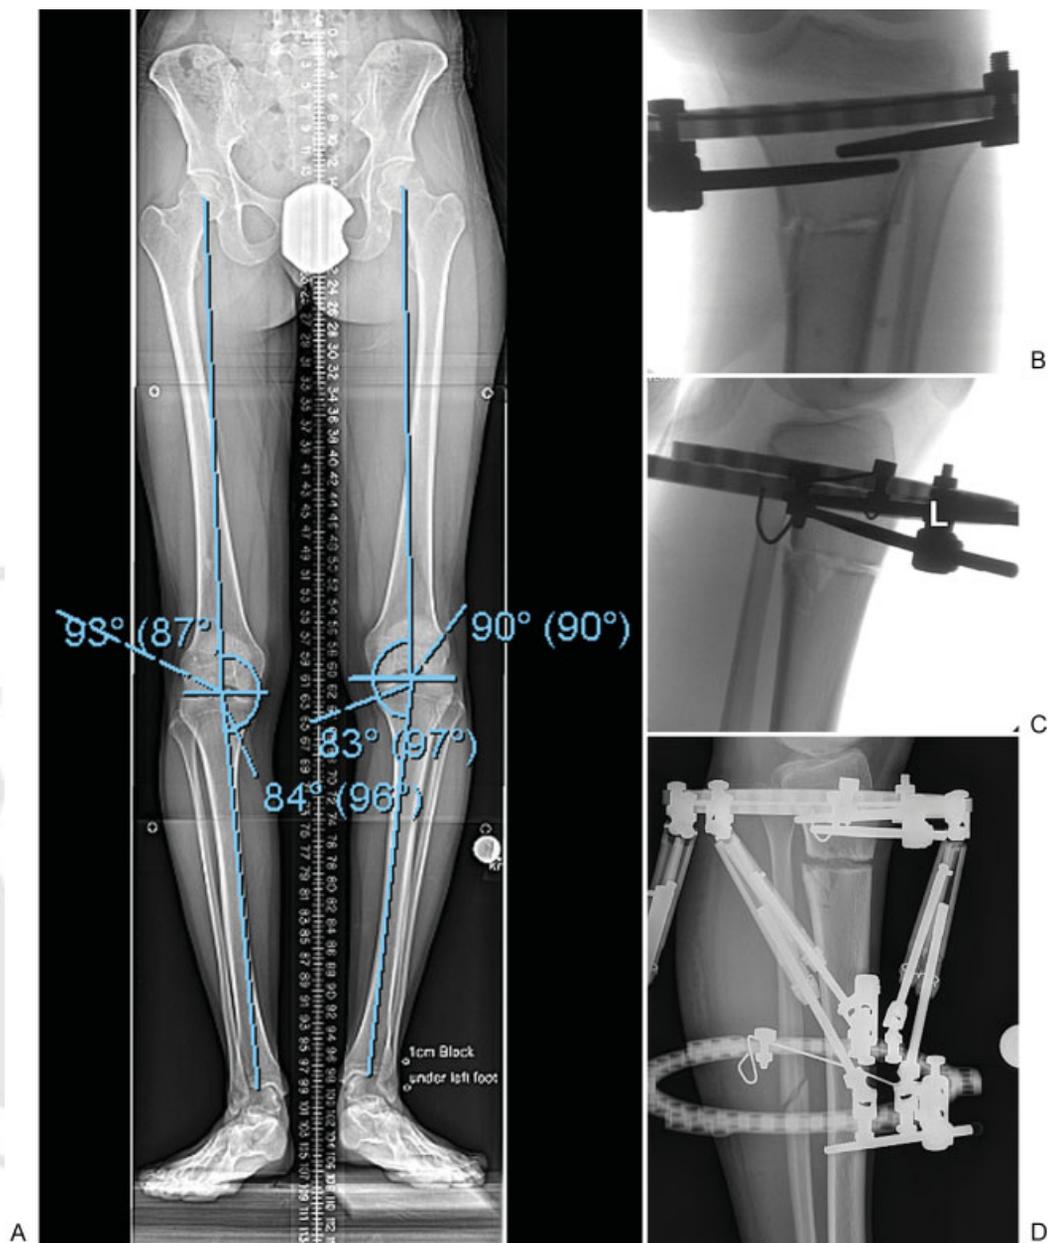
(A) Continuing with the patient shown in ►Fig. 1, the joint orientation angles are measured demonstrating abnormal MPTA and normal mL DFA. Note the external rotation of the ankles with the patellas pointing forward. (B) The intraoperative fluoroshot shows an AP of the completed osteotomy. (C) The lateral of the same surgery shows the osteotomy with some comminution which had no impact on the outcome. Her PPTA was 75 degrees and her knee came to full extension; therefore, the tibial slope was not altered. (D) This radiograph of the same patient demonstrates the oblique fibular osteotomy made in the mid-diaphysis where the surgery is technically simplified due to less soft tissue. AP, anteroposterior; mL DFA, mechanical lateral distal femoral angle; MPTA, medial proximal tibial angle; PPTA, posterior proximal tibial angle.
